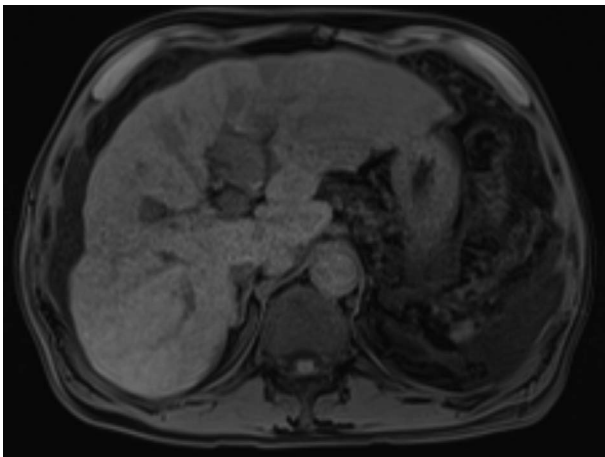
Liver. MRI. T1 weighted. Fat suppression. Precontrast. Axial plane.
